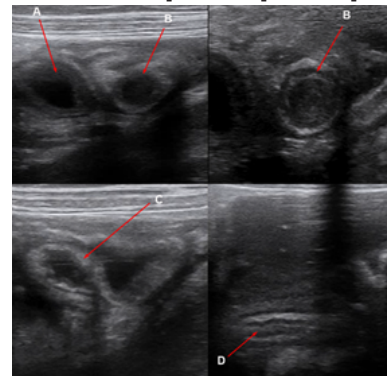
Ultrasound images of ileoileal intussusceptions & parasitic infestation: A & B: Target signs in the right lumbar region; C: Sandwich sign in the right paraumbilical region. D: Tubular echogenic structure (*Ascaris*) seen in the bowel lumen.
